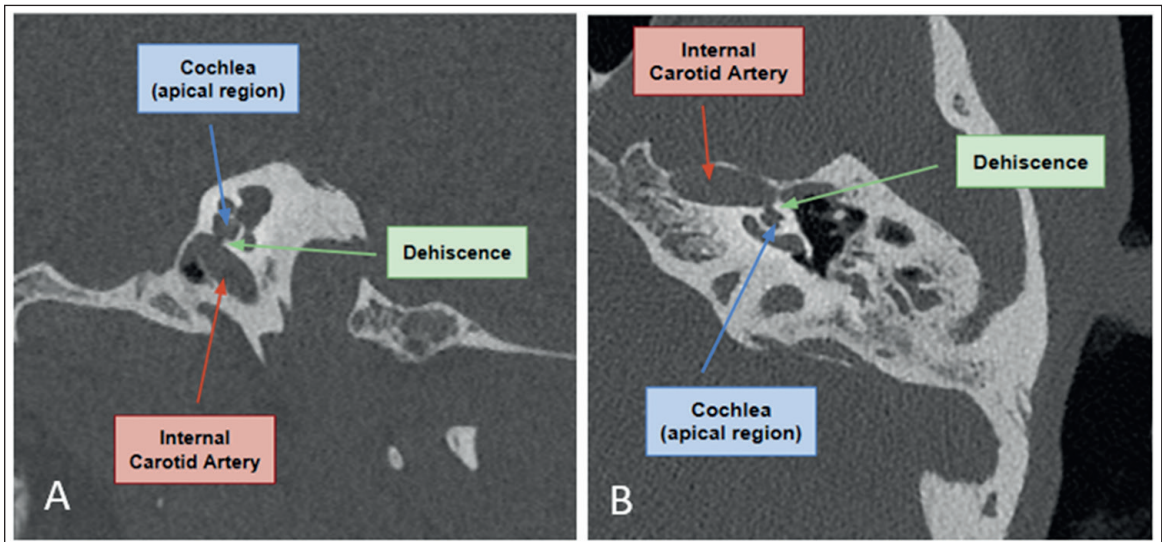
Computed tomography image of the left petrous bone in the sagittal plane (A) and axial plane (B). Cochleo-carotid dehiscence is observed (green), with a lack of bony coverage between the apical region of the cochlea (blue) and the carotid canal (red).
